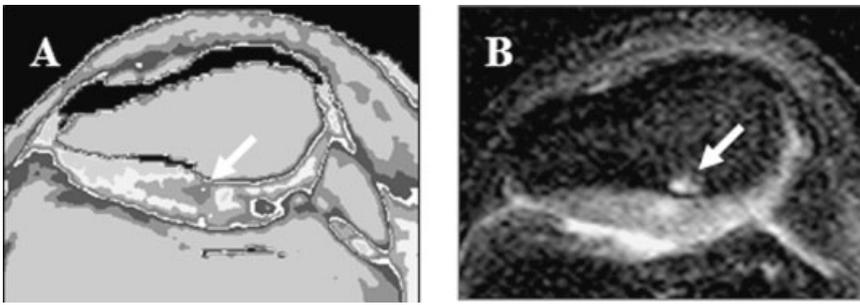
(A) Color T2 map demonstrating focally elevated cartilage T2 localized to the radial zone of cartilage in a patient with chronic anterior knee pain. (B) Corresponding clinical FSE T2-weighted image with fat suppression demonstrates elevated signal intensity at the site of measured high T2 values and associated high signal in the adjacent subchondral marrow.
